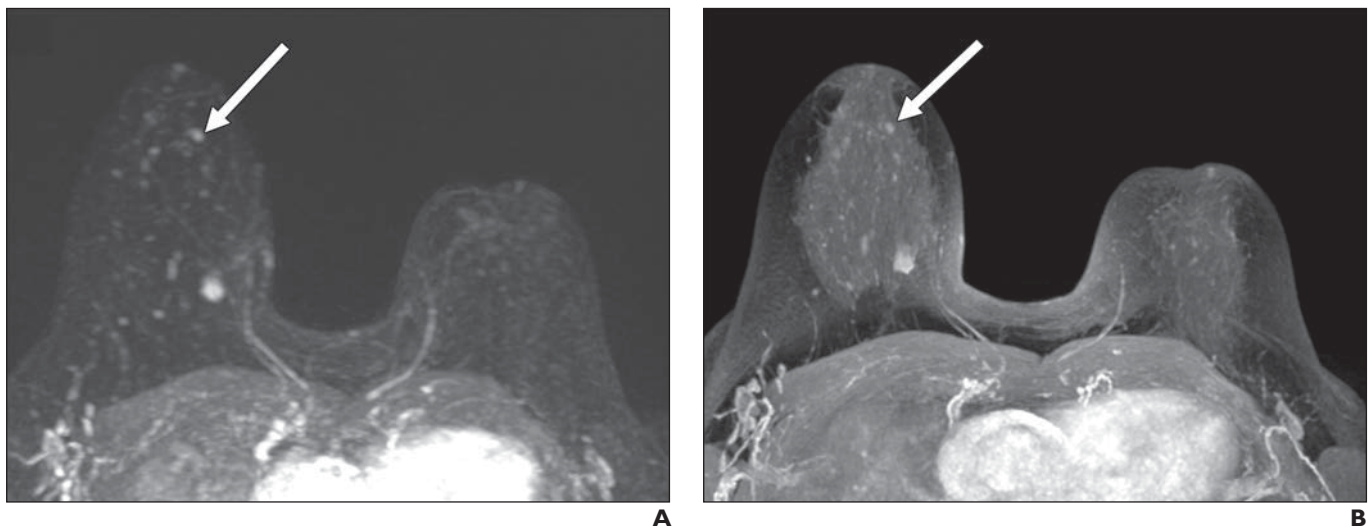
Steps for analyzing breast MRI including ultrafast sequence. 70-year-old woman who underwent breast MRI for staging of mass (lobular carcinoma of superior and medial quadrant of right breast). She had undergone tumorectomy for contralateral breast carcinoma 4 years before.
